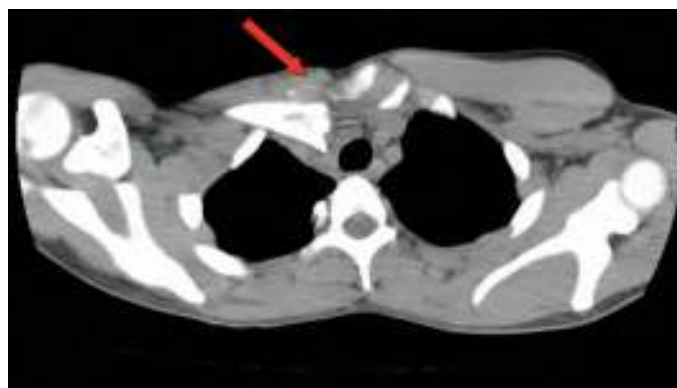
CT scan of a posterior sternoclavicular joint dislocation. (Used with permission from Tintinalli JE, et al: *Tintinalli's Emergency Medicine: A Comprehensive Study Guide*, 8th ed. New York: McGraw-Hill; 2016.)
